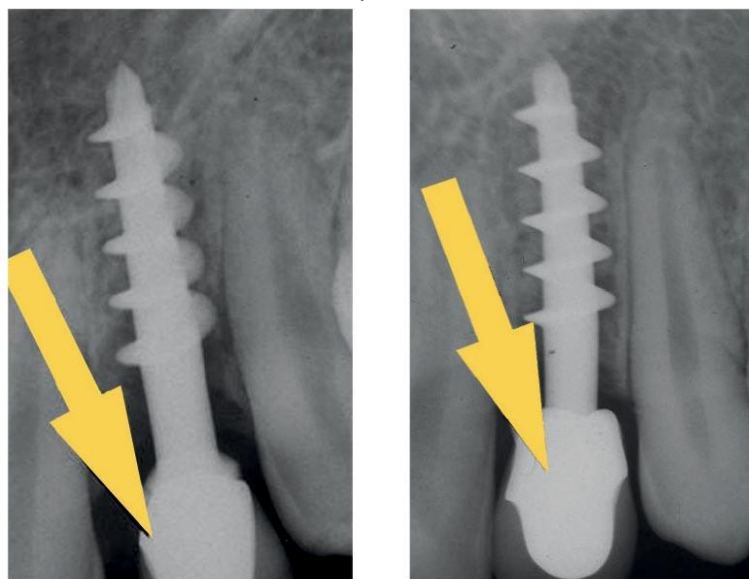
Radiographic control. In the image on the right, the amazing healing of the peri-implant bone tissue is evident.
